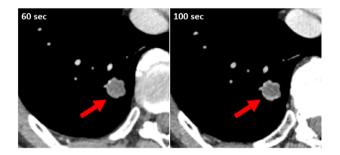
Contrast-enhanced CT showing the peripheral nodular enhancement in late phase (100 s)
